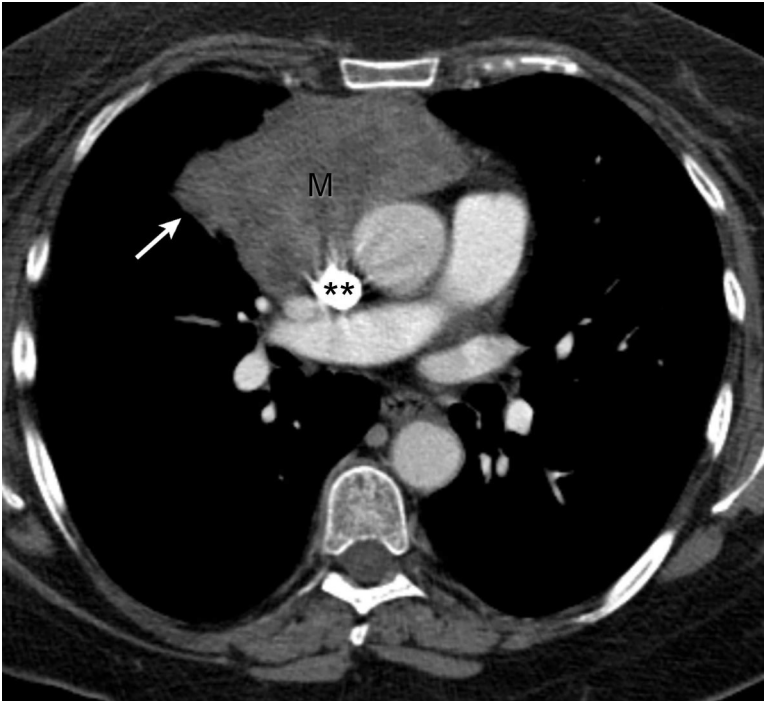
T3 tumor. Contrast-enhanced axial CT of the chest demonstrates a prevascular mediastinal mass (M), which forms a lobular border with the lung (*arrow*) and surrounds a portion of the superior vena cava (*double asterisk*). At surgery, a thymoma was diagnosed and involvement of the lung and superior vena cava was confirmed, the findings of which are consistent with T3 disease.
